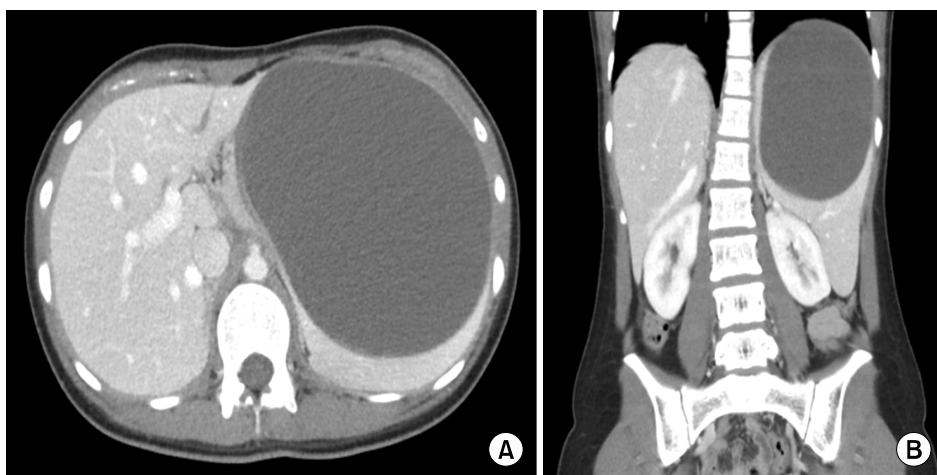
Abdominal CT scan shows a large splenic cyst with scoliosis. (A) Axial view, (B) Coronal view.
